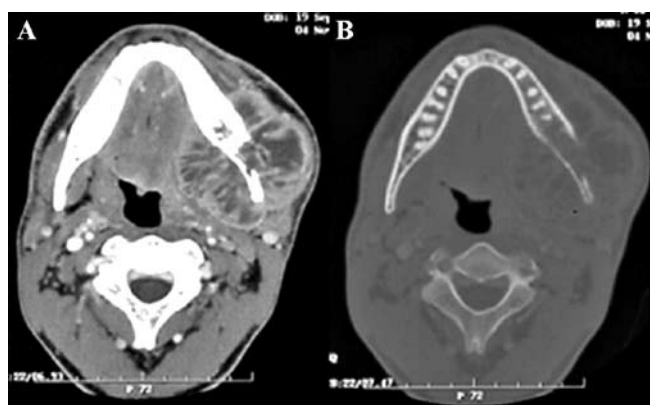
A 32-year-old male affected by bulky osteosarcoma originating from left posterior body of mandible, completely enclosed within MS by fascial layers, correctly diagnosed by both CT (2.1: A. soft tissue window; B. bone window) and MRI (2.2: A. axial STIR sequence; B. axial T2 weighted sequence; C. coronal T1 weighted sequence after gadolinium administration).
